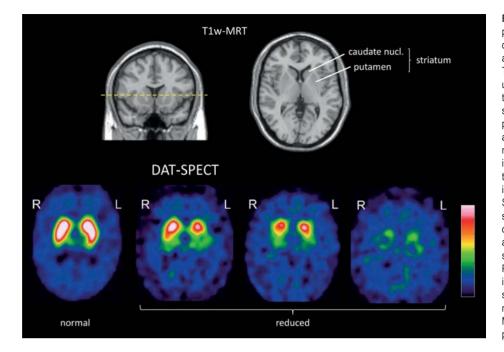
Typical DAT-SPECT findings in patients with idiopathic parkinsonian syndrome (IPS) showing reduced striatal DAT availability compared with a normal findng. The reduction is often left/right asymmetrical, usually more pronounced in the hemisphere that is contralateral to the clinically dominant side of the body (e78). The (posterior) putamen is almost always most strongly affected (e79). Motor symptoms in IPS manifest only after a DAT loss of about 50% in the putamen (14). A strong reduction in tracer uptake in the (contralateral) putamen is therefore the minimum finding on DAT-SPECT in IPS. A reduction that is only slight should as a rule not be seen as an indication of nigrostriatal degeneration (40, e80). The atypical neurodegenerative parkinsonian syndromes, especially PSP and MSA of the Parkinson type, show similar patterns of findings on DAT-SPECT as IPS (9). DAT-SPECT, single photon emission computed tomography with dopamine transporter ligands; MSA, multiple system atrophy; PSP, progressive supranuclear palsy
